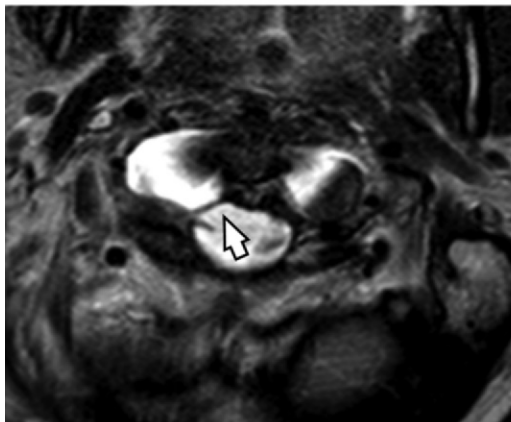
Transverse ligament. Axial T2-weighted MR image shows the transverse ligament (arrow) spanning from the lateral masses of the atlas.
